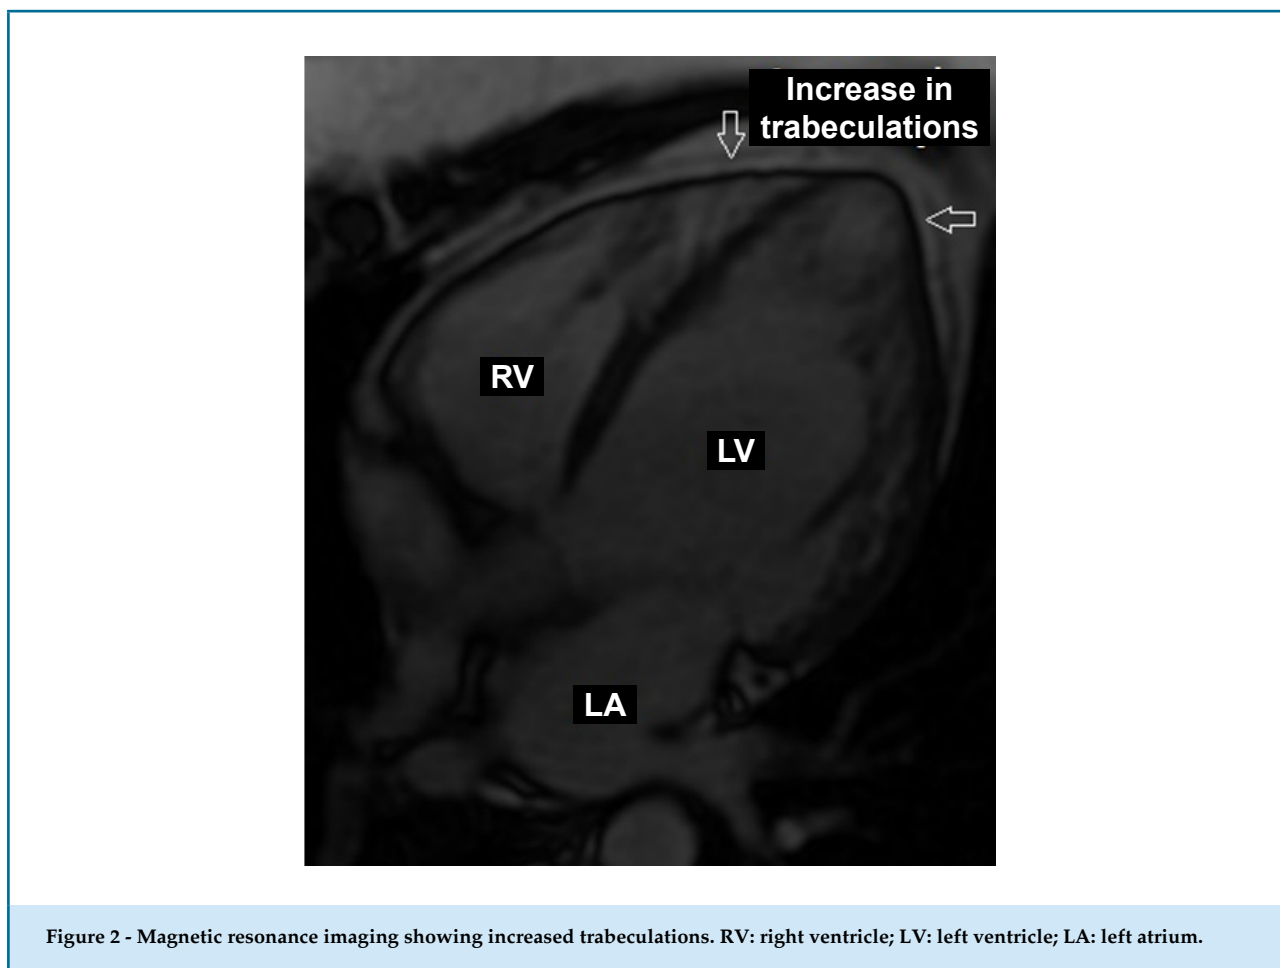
Magnetic resonance imaging showing increased trabeculations. RV: right ventricle; LV: left ventricle; LA: left atrium.
